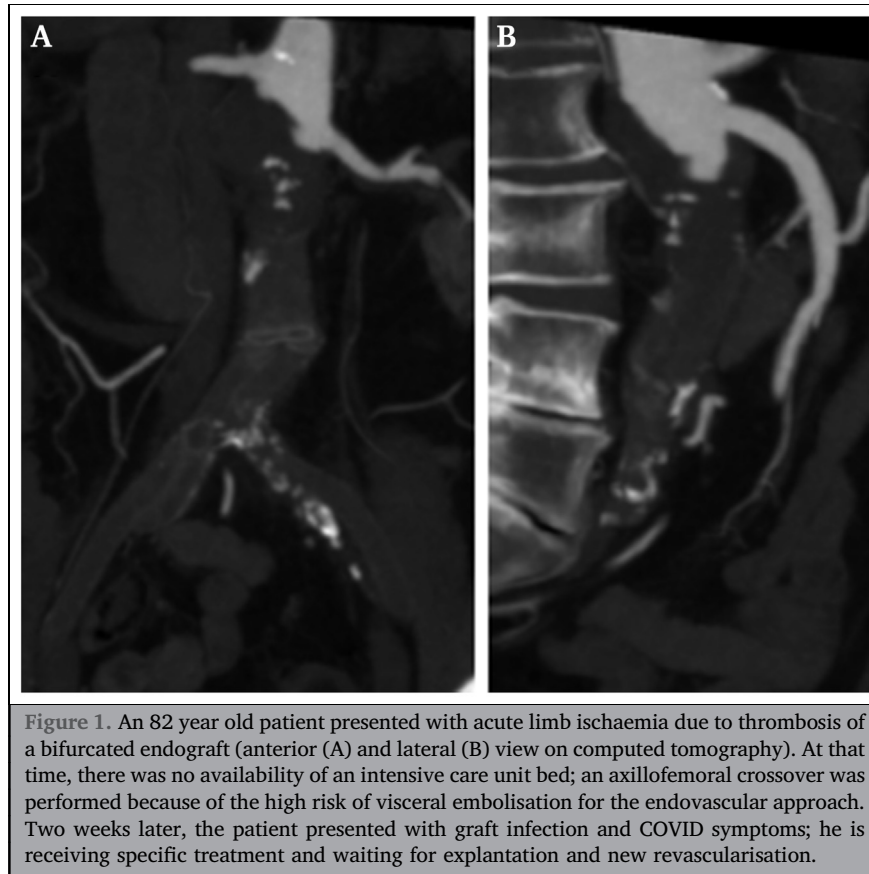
An 82 year old patient presented with acute limb ischaemia due to thrombosis of a bifurcated endograft (anterior (A) and lateral (B) view on computed tomography). At that time, there was no availability of an intensive care unit bed; an axillofemoral crossover was performed because of the high risk of visceral embolisation for the endovascular approach. Two weeks later, the patient presented with graft infection and COVID symptoms; he is receiving specific treatment and waiting for explantation and new revascularisation.
